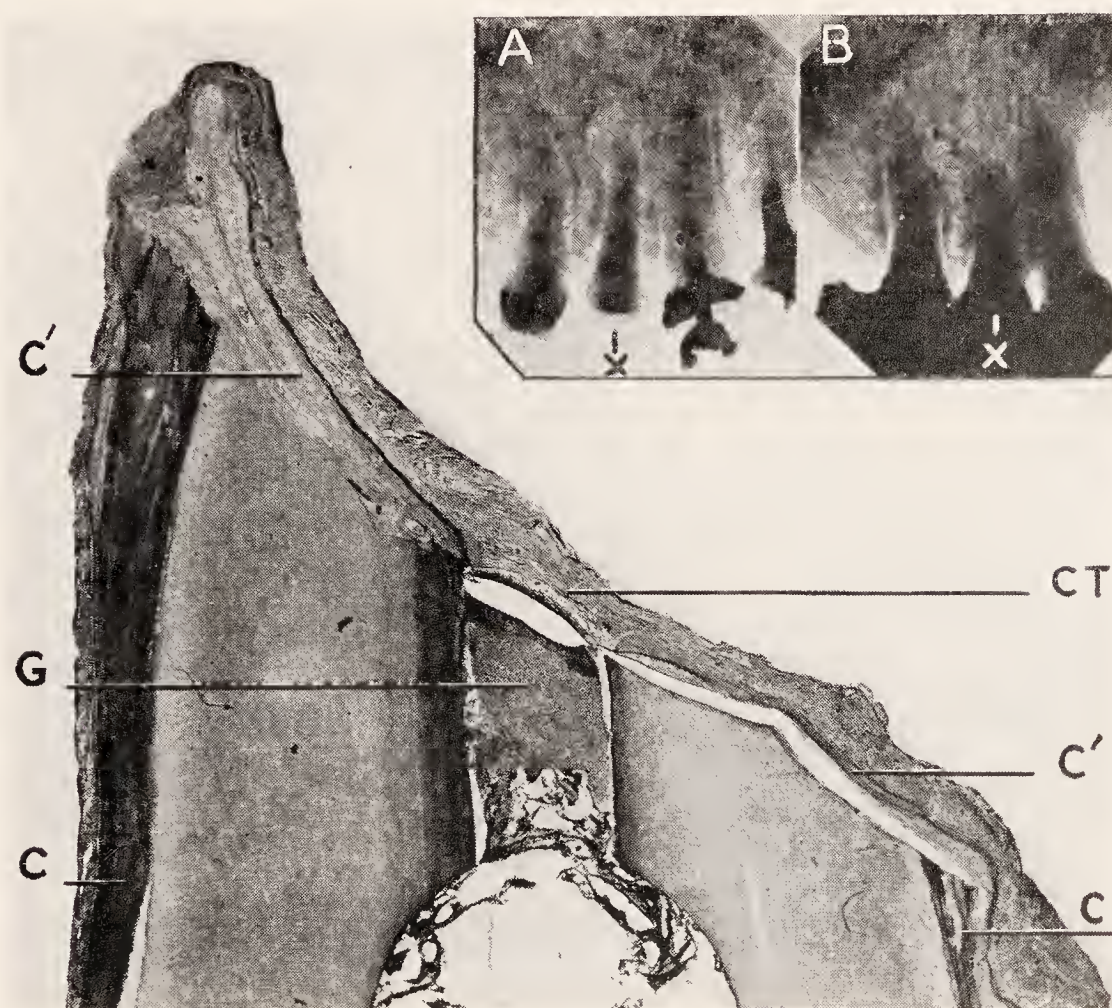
Tissue healing following root resection. A, radiograph of an upper second bicuspid with imperfect root canal filling and marked destruction of the periapical bone. This radiograph was taken in 1914, immediately before the root resection was performed. B, same tooth as it appeared in 1928. The area formerly occupied by the apex and the granuloma is entirely filled in by bone. Bucco-lingual section through resected root end. Deposition of cementum and regeneration of a normal periodontal membrane on the resected surface. G, guttapercha root canal filling; C, original cementum on root surface; C', newly deposited cementum on the resected root surface; CT, connective tissue capsule bridging the root filling material. (Coolidge, Jour. Am. Dent. Assn.)
